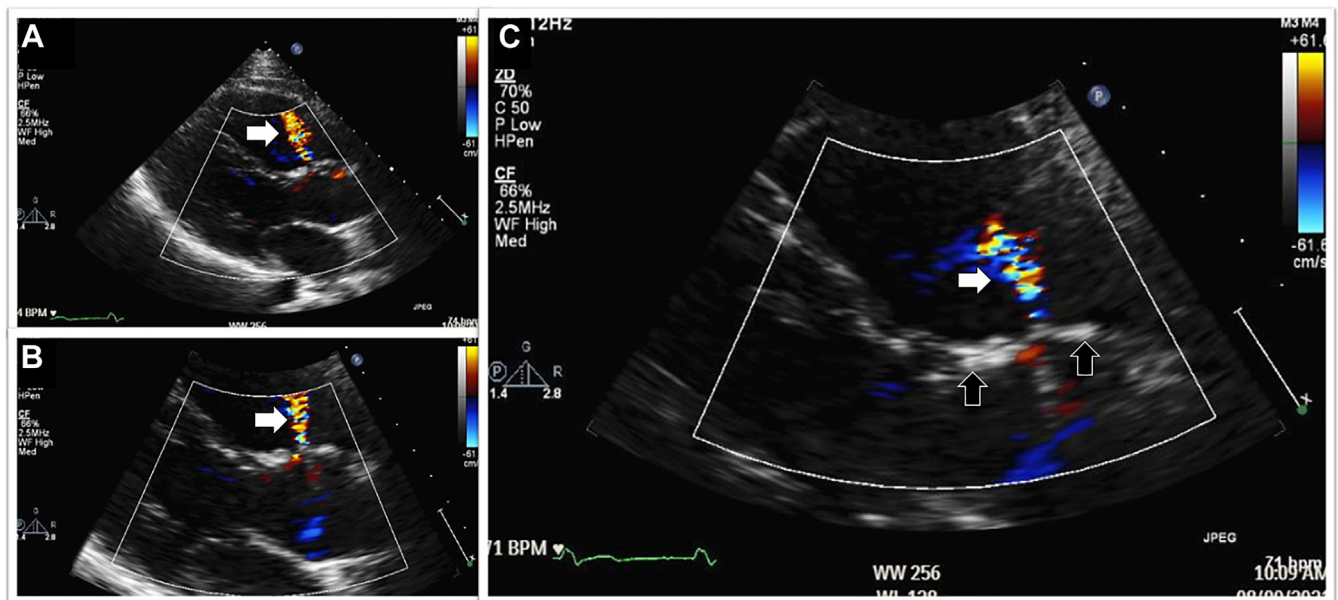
When CMR fails. This patient with tetralogy was noticed to have a loud systolic murmur that was out of keeping with expected physical findings. Pulmonary or RVOT stenosis was suspected clinically, and the patient underwent CMR, which failed to identify the cause. (A-C) Subsequent echo colour Doppler clearly demonstrated a small residual restrictive VSD with a systolic jet (arrow) through a tiny hole in the artificial (and hyperechogenic) VSD patch (black arrows). CMR, cardiac magnetic resonance; RVOT, right ventricular outflow tract; VSD, ventricular septal defect.
